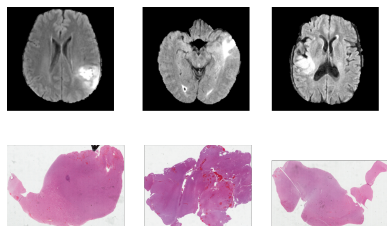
Examples of MRI and WSI exams for three different patients.
